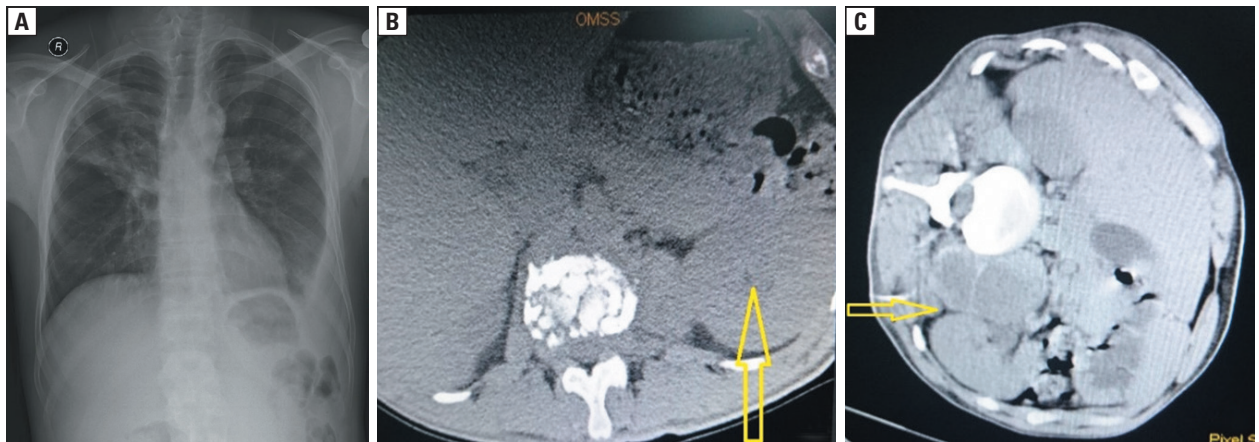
A. Chest radiograph on presentation: posteroanterior view; B. lumbar region computed tomography (CT); C. CT-guided abscess drainage
